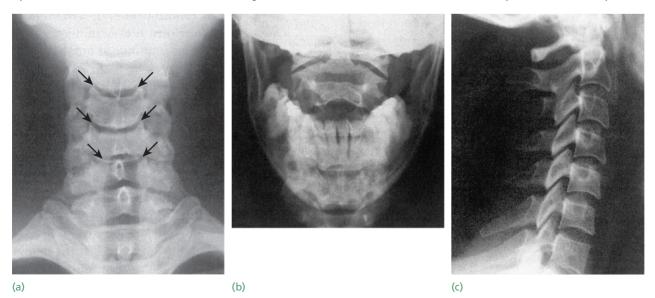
Imaging – normal X-rays (a) Anteroposterior view – note the smooth, symmetrical outlines and the clear, wide uncovertebral joints (arrows). (b) Open-mouth view – to show the odontoid process and atlanto-axial joints. (c) Lateral view – showing all seven cervical vertebrae.
